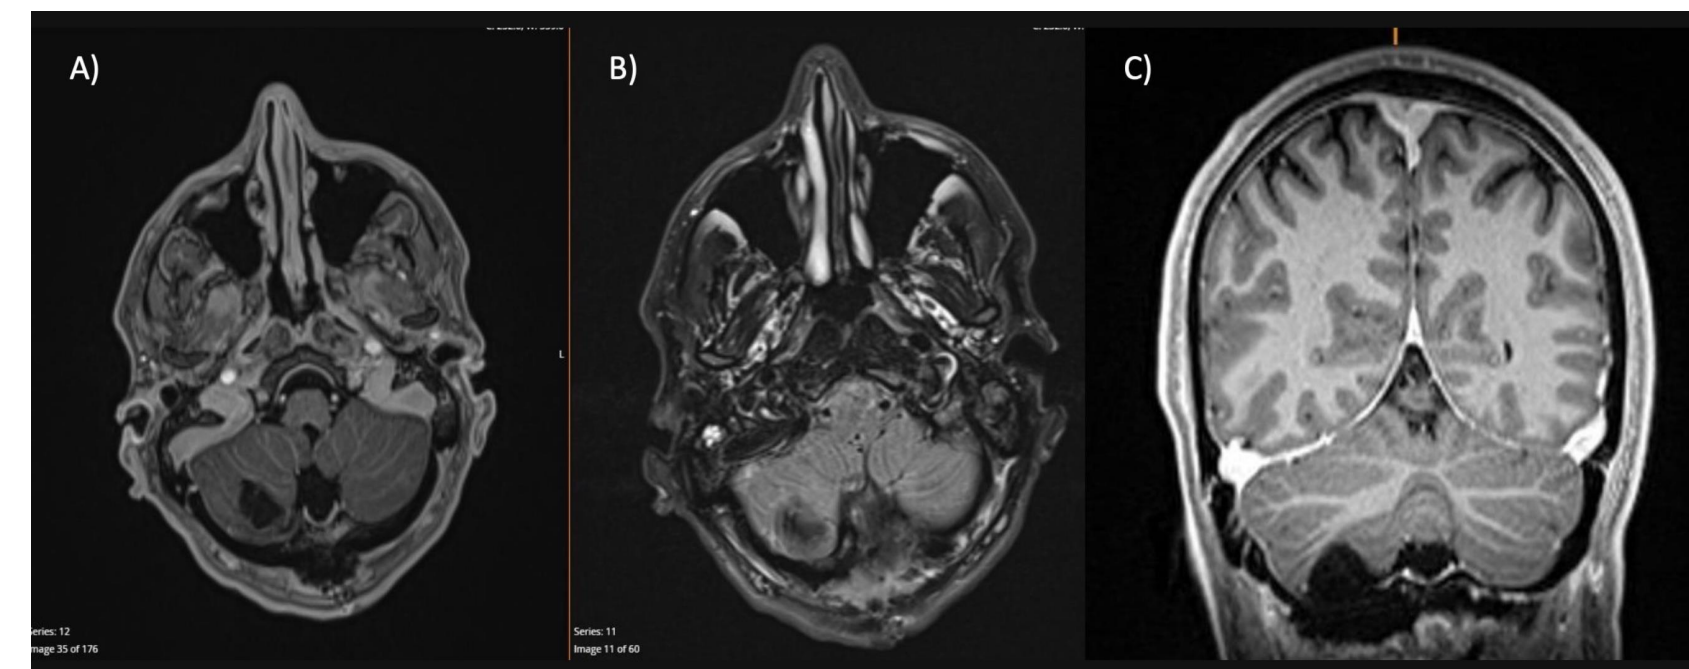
Post-operative MRI demonstrates gross total resection. Post-operative MRI Brain with contrast: A) axial T1 post-contrast B) axial T2 FLAIR c) coronal T1 post-contrast. All panels depict the post-surgical changes of a suboccipital craniotomy with complete resection of the posterior fossa dural-based mass.
